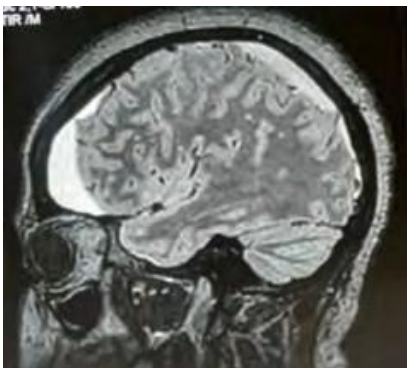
Cerebral MRI represented on Sagittal Frame
